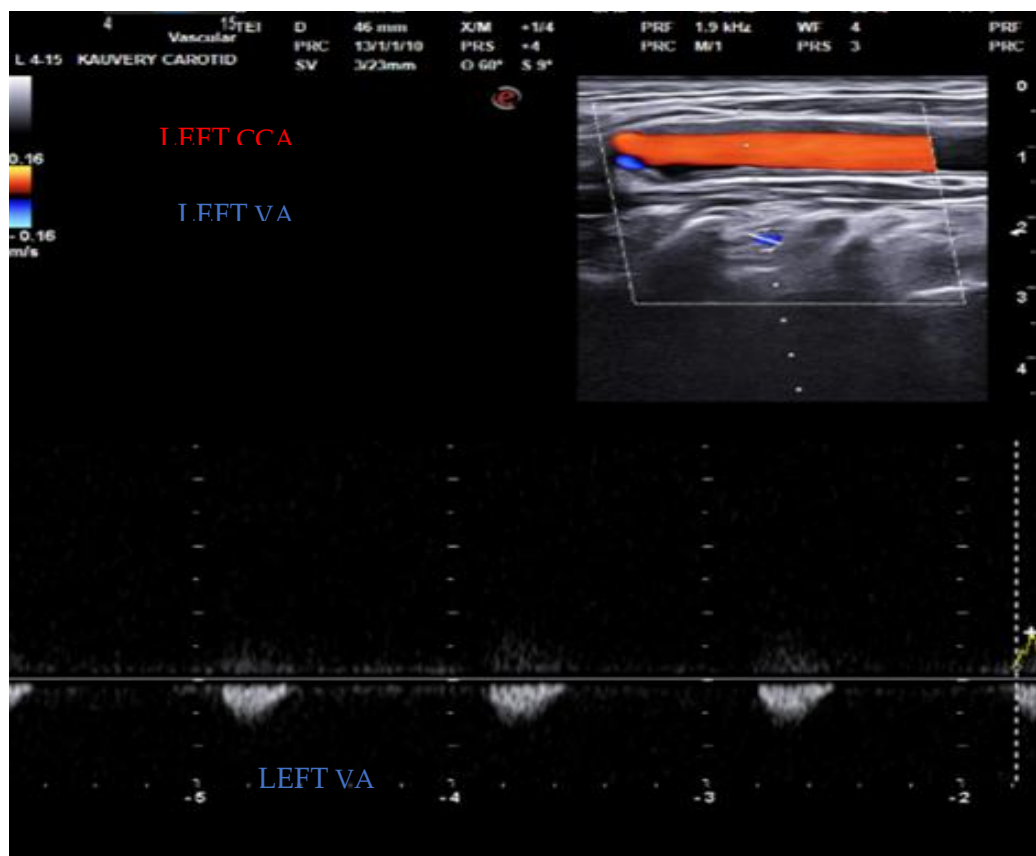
Duplex colour doppler ultrasound showing flow reversal in the left vertebral artery
